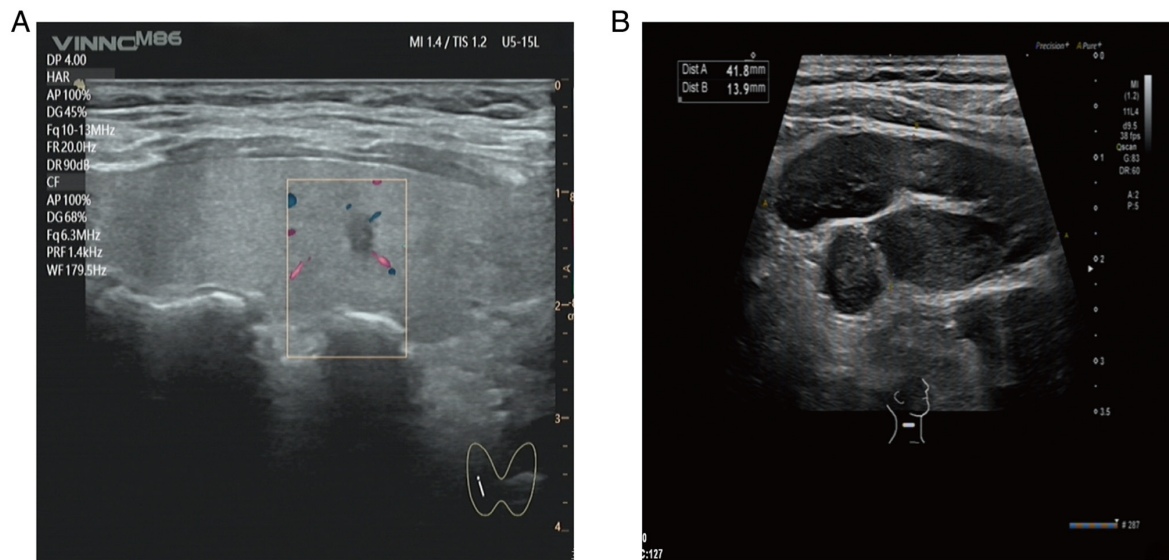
Neck ultrasonography. (A) Hypoechoic thyroid nodule in the right lobe (Thyroid Imaging Reporting and Data System 4a). (B) Enlarged cervical lymph node, with the largest node measuring $\sim 3.1 \times 1.0$ cm on the right side and 1.5×1.0 cm on the left side.
